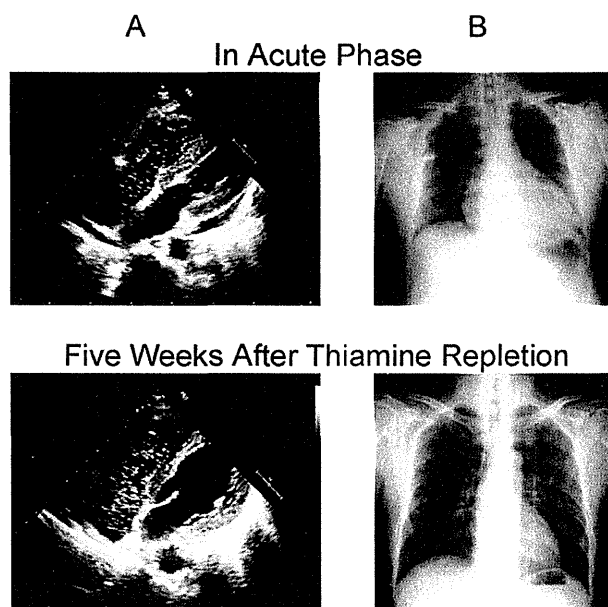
(A) Contrast-enhanced echocardiography and (B) chest X-rays in the acute phase and 5 weeks after the thiamine repletion. In the acute phase, microbubbles opacified the left atrium seven cardiac cycles after the initiation of right-atrial opacification (A, upper panel), whereas 5 weeks after the thiamine repletion, microbubble opacification became negative (A, lower panel). (B) The chest X-rays display improvement of cardiomegaly and congestion during this period.
